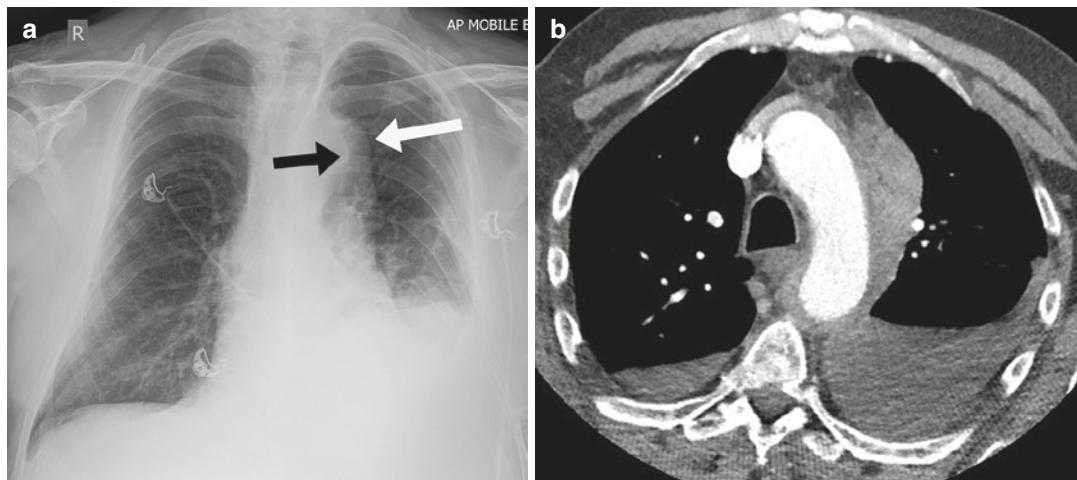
AP radiograph (a) demonstrates widening of the superior mediastinum in an 83-year-old man, with the apparent contour of the aorta (white arrow) extending beyond the crescent of atherosclerotic calcification (black
